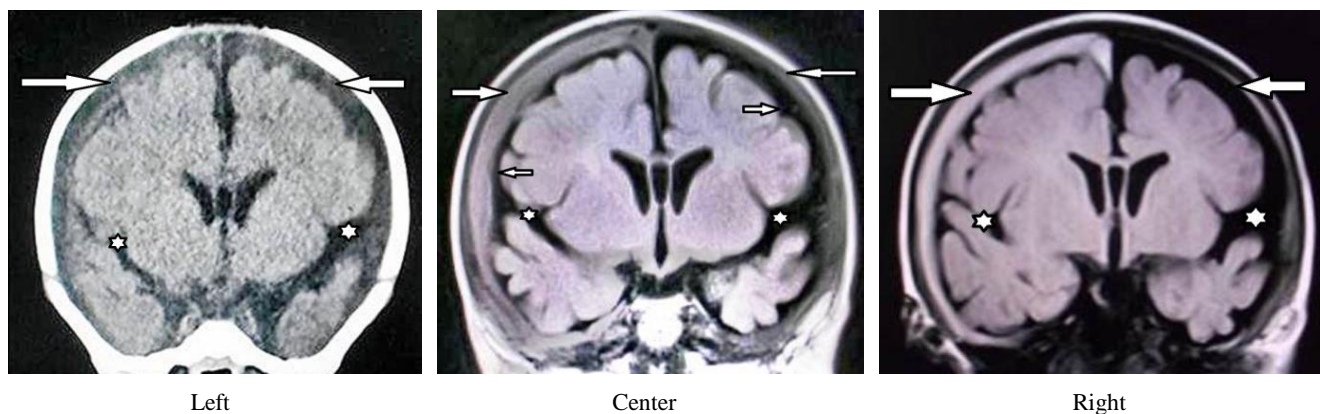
Case 1 (No. 3), female aged 2 months; Left: CT, coronal view on arrival demonstrating large, bilateral, extra-axial fluid collections. The hyperintensity was slightly greater on the right side than in the CSF. (arrows); Note the large, bilateral sylvian fissures. (R>L, stars); Center: Coronal view on magnetic resonance imaging (fluid-attenuated inversion recovery, FLAIR) three days after onset showing a bilateral area of higher signal intensity in the extra-cerebral fluid collections than in the CSF, indicating ASDHy. BESS was also observed (R>L, small arrows). Note the large, bilateral sylvian fissures on both sides (R>L, stars). No mass effect or parenchymal abnormality was observed on the other sequences (not shown). Right: Coronal view on MRI (FLAIR) 21 days after onset showing decreased ASDHy (arrows). Note the large, bilateral sylvian fissure (R>L, star).
